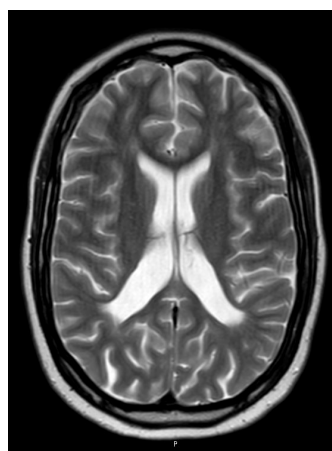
T2-WI MRI shows mild periventricular hyperintense confluent T2 signal abnormalities, likely demyelination.
